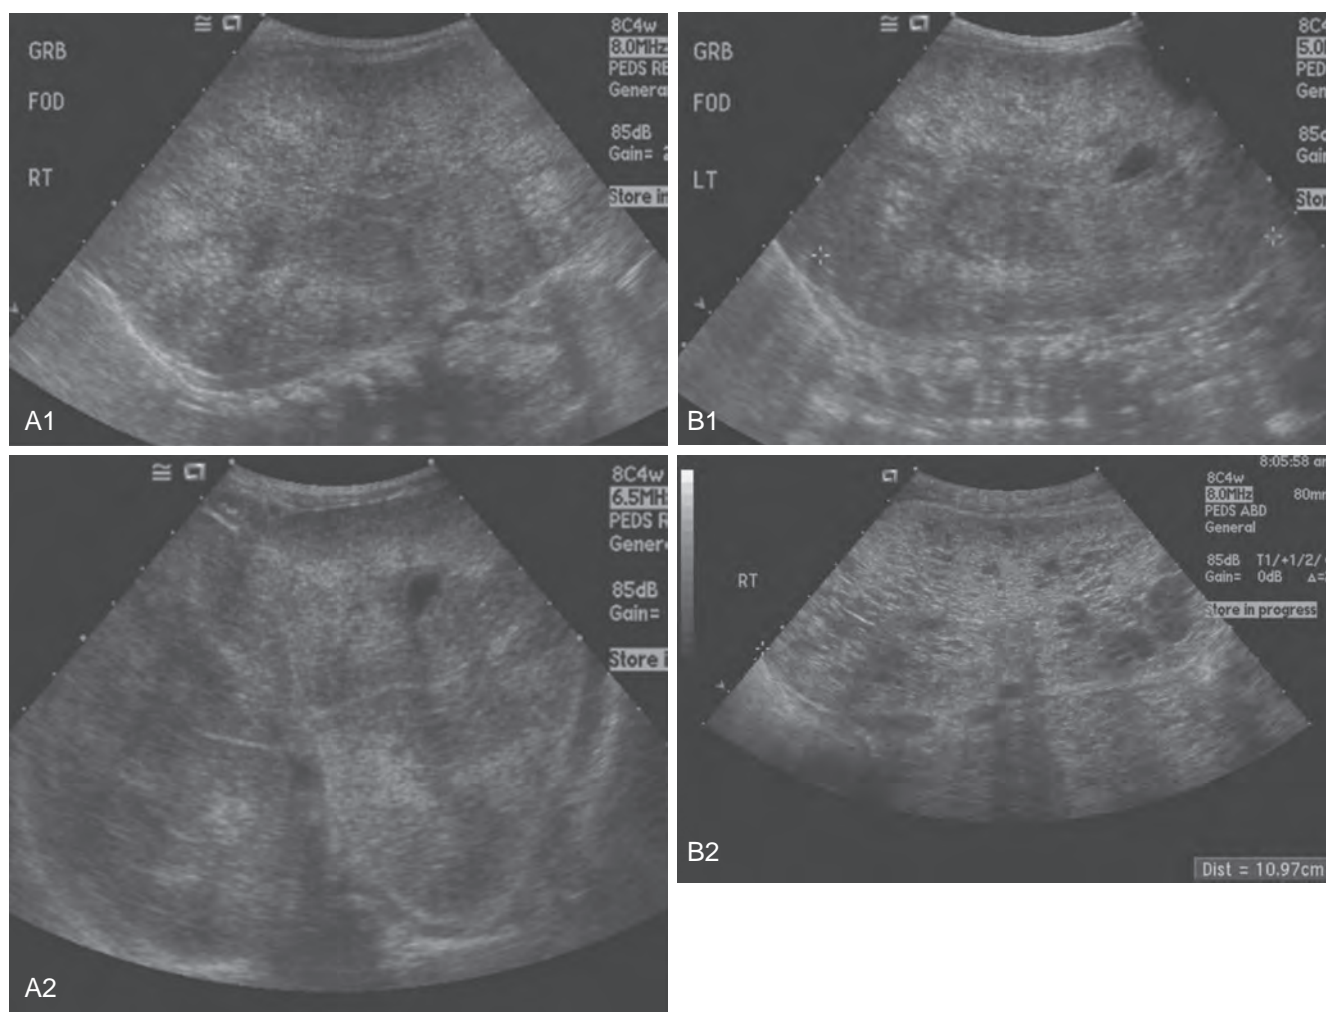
Ultrasonographic appearance of the kidneys in neonates with autosomal recessive polycystic kidney disease (ARPKD) and autosomal dominant polycystic kidney disease (ADPKD) can be similar. A1 and A2, Newborn with ARPKD. Note the large size and hyperechoic, homogeneous appearance of the renal parenchyma. A2 is a cross-sectional cut of the baby's abdomen showing both kidneys to be quite large and occupying a large portion of the abdominal cavity. B1 and B2, Newborn with ADPKD. Again note the abnormal renal architecture and the hyperechoic appearance of the kidneys. The parenchyma consists of multiple tiny cysts, with some being slightly larger than others. (Courtesy Marta Hernanz-Schulman, MD.)
